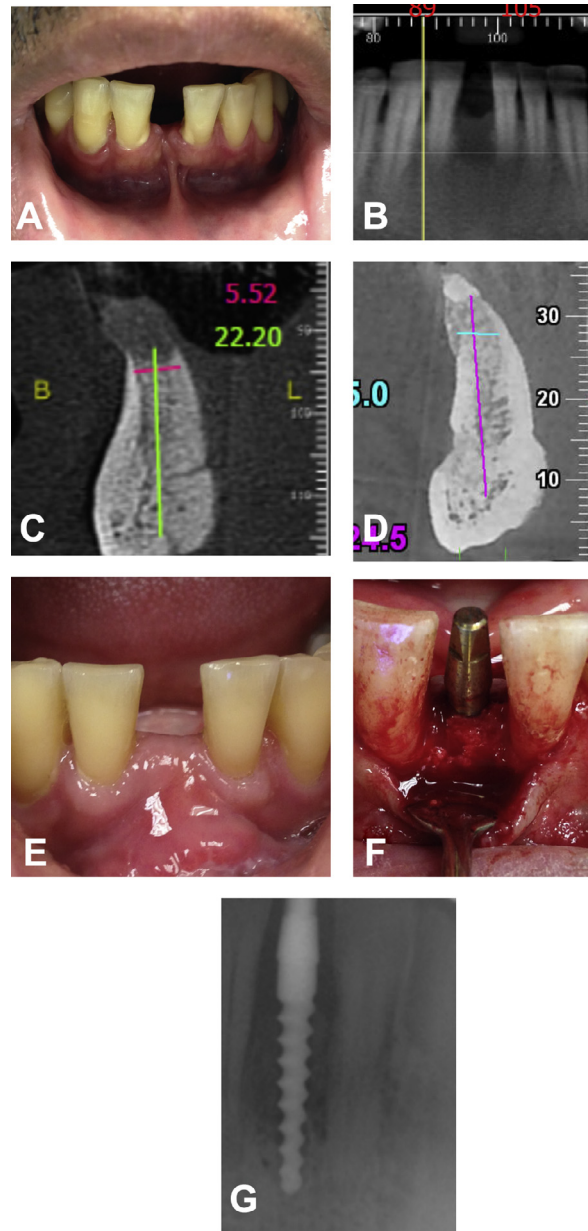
Case 1: Clinical evaluation of alveolar ridge missing single incisor (A), cone beam computed tomography (CBCT) demonstrating localized alveolar defect (B), preoperative CBCT demonstrating a vertical osseous defect (C), CBCT demonstrating alveolar bone gain 4 months after treatment (D), postoperative evaluation of the surgical site during the consolidation period (E), preprosthetic implant placement within the augmented site (F), and periapical radiograph demonstrating the postoperative implant site (G).
